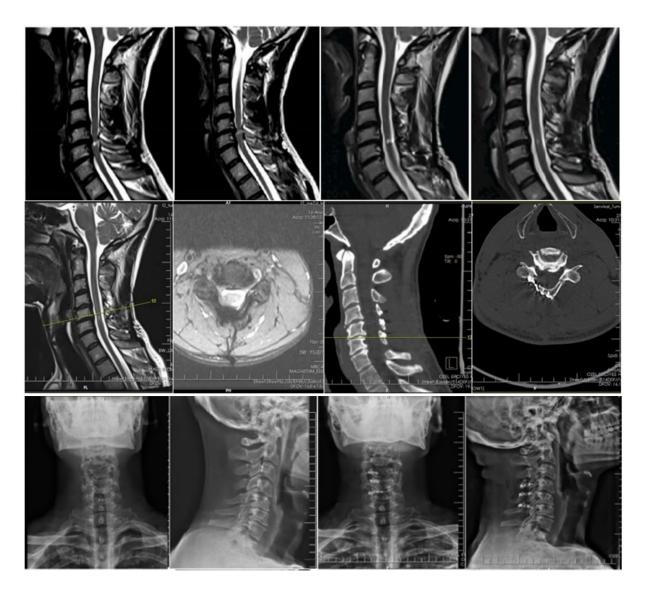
Preoperative (left two) – postoperative (right two) MR/CT/CR (in order from top to bottom) results of a patient with cervical stenosis.
